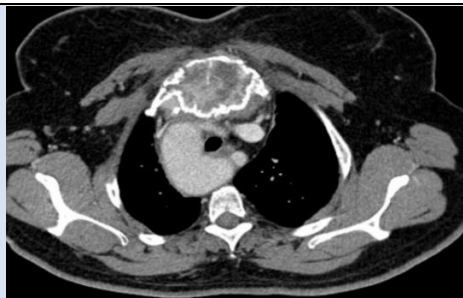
Axial section of an injected CT-scan, focused on the sternal mass
